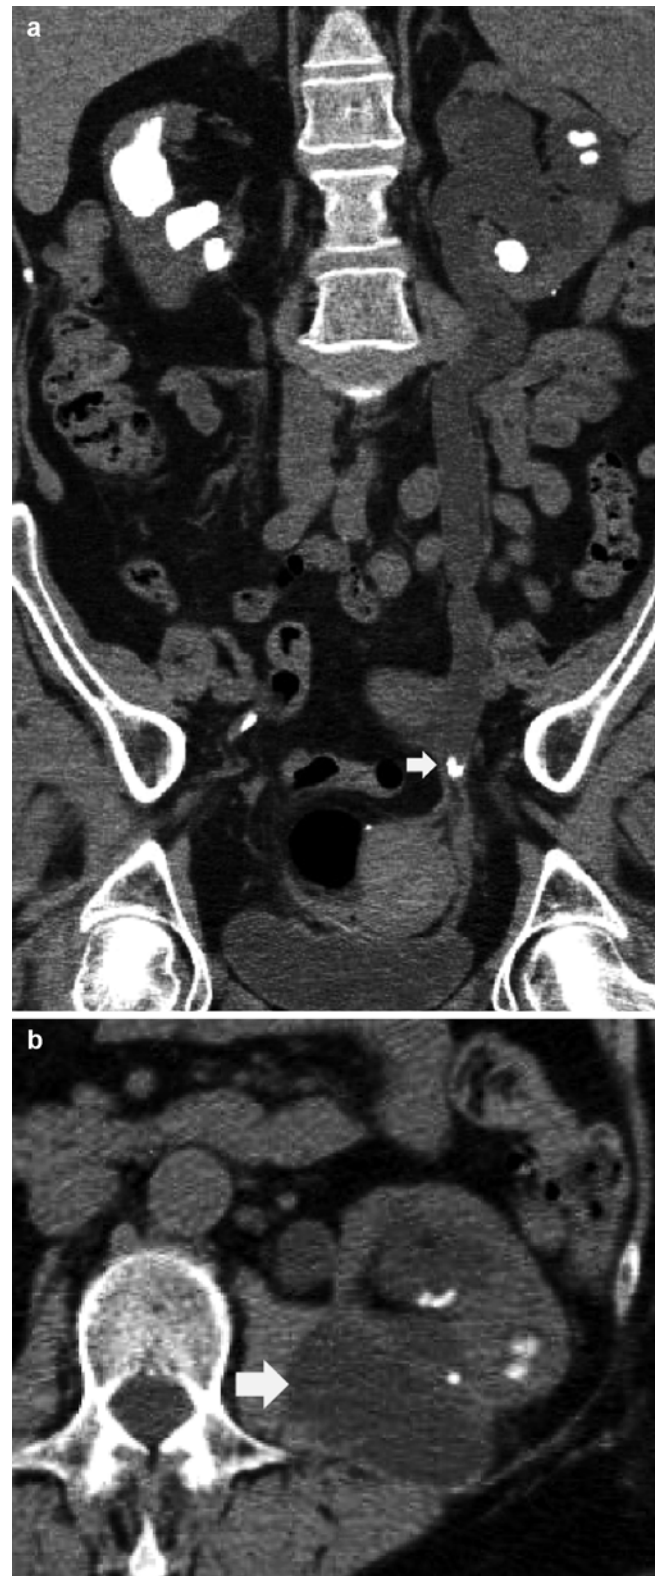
Indirect signs of renal calculi. (a) Unenhanced CT. Coronal reformation. Left urinary tract dilatation due to an obstructing ureteral stone (arrow). Multiple renal calculi are evident on the left kidney, while staghorn calculosis is depicted on the right kidney. (b) Unenhanced CT. Transverse plane. Perirenal urinoma (arrow) (Courtesy of Prof. E. Quaia)
